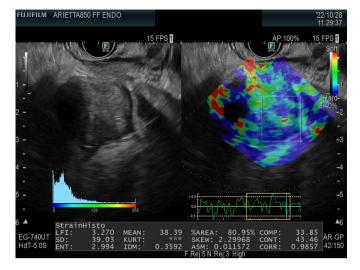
Endoscopic ultrasound-guided strain elastography of a solid pancreatic mass, showing the typical heterogeneous blue predominant pattern, with a strain histogram of 38.39.
